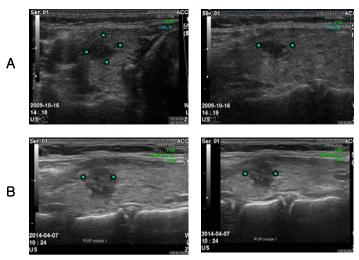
Sonographic Findings
